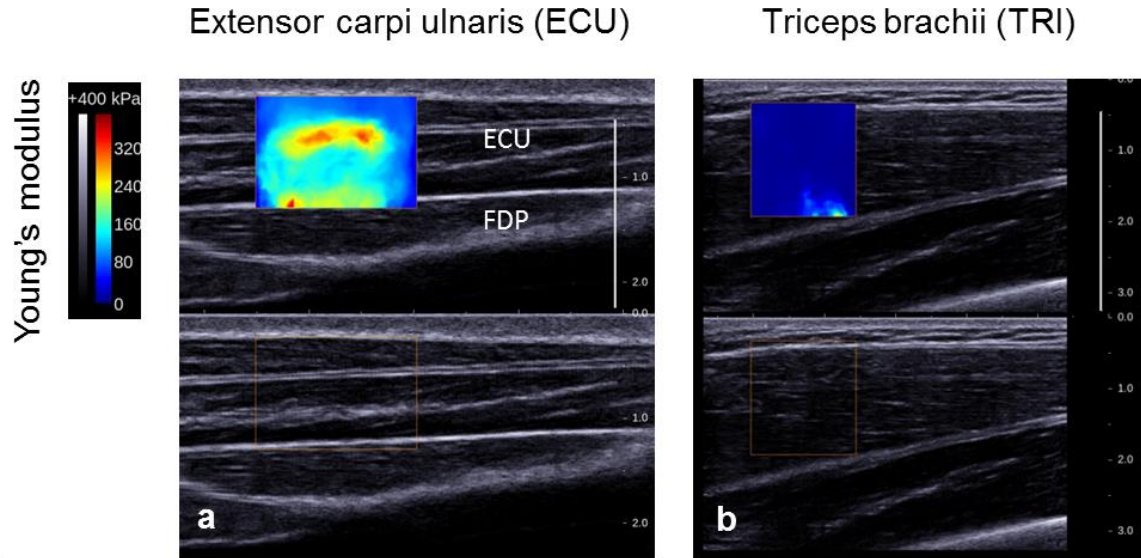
Representative ultrasound images of the extensor carpi ulnaris (ECU) (a) and the triceps brachii (TRI) (b). A colored box over the B-mode image (*top*) shows the region of interest (ROI) selected for the elastography recording. The long white bands of tissue across the middle of each image are connective tissue. The flexor digitorum profundus (FDP) is shown deep to ECU.
